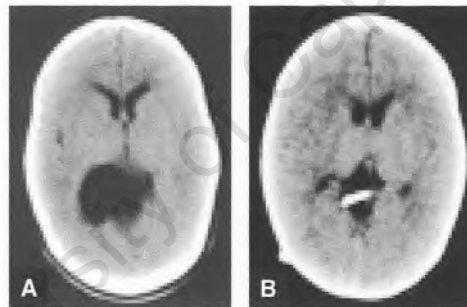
Initial axial CT scan (a) demonstrating the cyst located in the quadrigeminal cistern; the postoperative scan confirms placement along the intended stereotactic trajectory (b).
